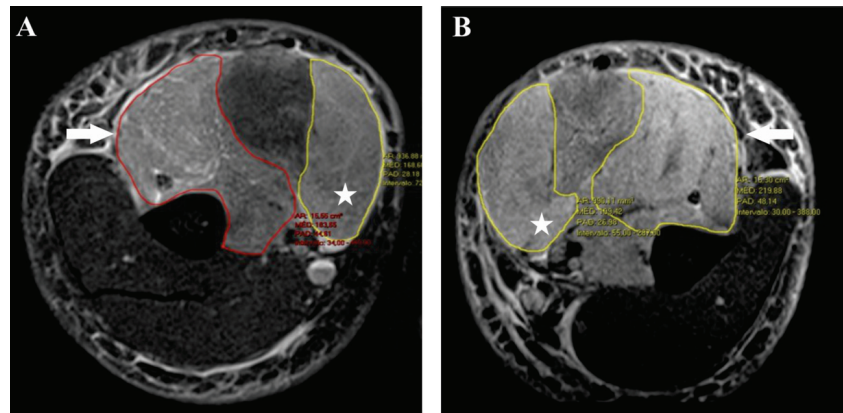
Magnetic resonance imaging of the arms, taken six days after the injury and after three days of HBO₂ treatment
